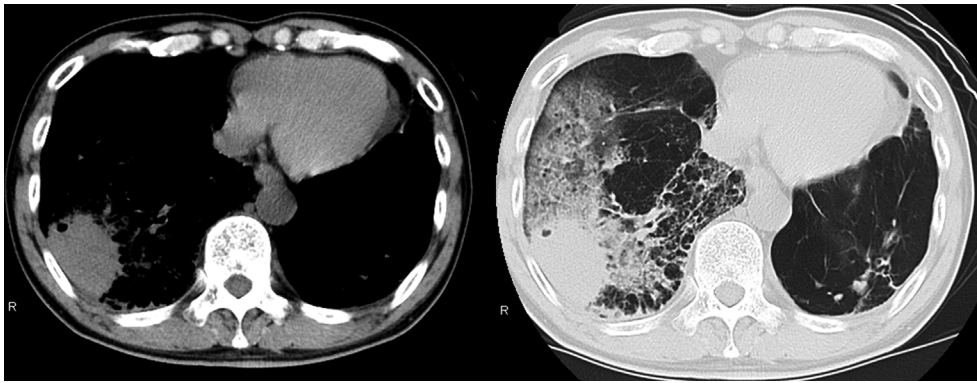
Chest computed tomographic image showed a gas-containing lung abscess in the right lower lobe.
